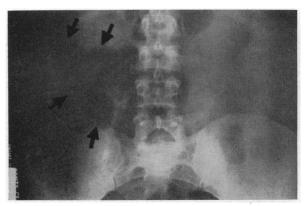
Ileus of hepatic flexure. The patient was a white woman 30 years of age who entered the hospital with a history of stabbing pain in the right upper quadrant of the abdomen following the ingestion of fatty foods. Nausea and vomiting were present. On the third hospital day the temperature reached 104°F. and leukocytes numbered 11,400 per cu. mm. A plain film of the abdomen showed a localized ileus of the hepatic flexure (arrows). The liver edge was obscured.
